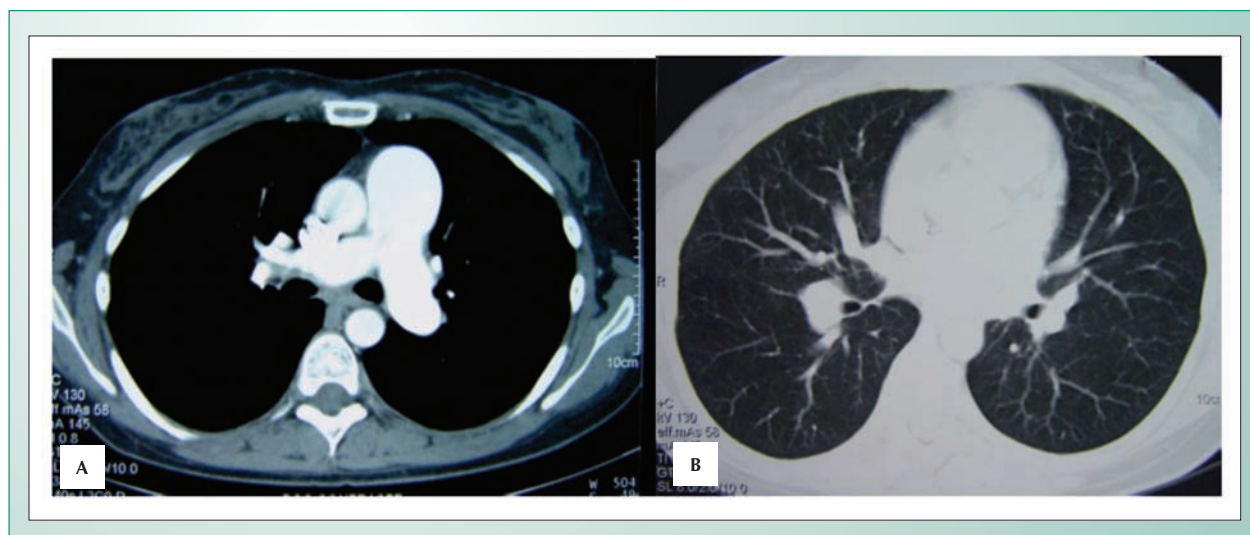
CT of thorax with suggestive signs of pulmonary hypertension: A) Mediastinal window at pulmonary artery trunk with increased diameter (>2.9 cm) and increased pulmonary artery and aorta ratio (>1); B) Parenchymal Window showing increased artery/bronchus ratio (>1).
